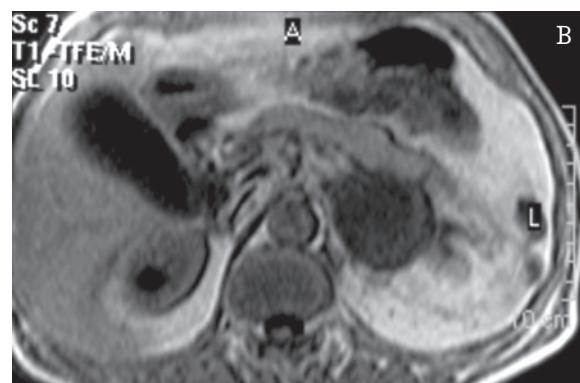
Male-patient aged 65 with left adrenal metastasis from lung carcinoma. A. Coronal T2-weighted image reveals large hyperintense tumor in the left adrenal gland as well as the lymph nodes along the aorta (adrenal mass SI: 878, liver SI: 485); T2 index 1.81. B. In-phase image demonstrates a hypointense adrenal tumor (SI: 324). C. Opposed-phase image does not show suppression of signal within the lesion (SI: 397) compared with the in-phase image; CSI ratio: -0.23.
